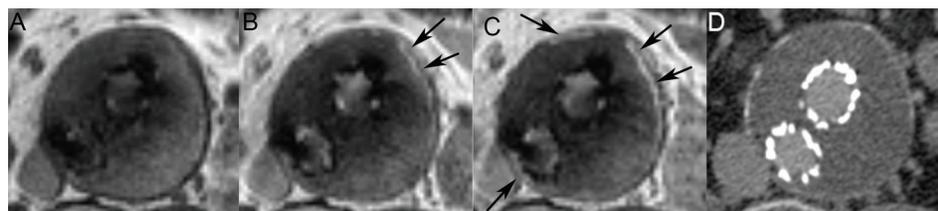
Patient no. 7 in Table 1. Stable aneurysm, 2 years after EVAR. Transverse precontrast(A), early postcontrast(B), late postcontrast(C) T1-weighted spin echo image (TR/TE 580 ms/15ms) and delayed CT(D) at the same location. In B) and C) arrows point to endoleak. Signal loss around stent in A), B), and C), are due to metal-induced susceptibility artifacts caused by stent components. In D) no endoleak is visible.
